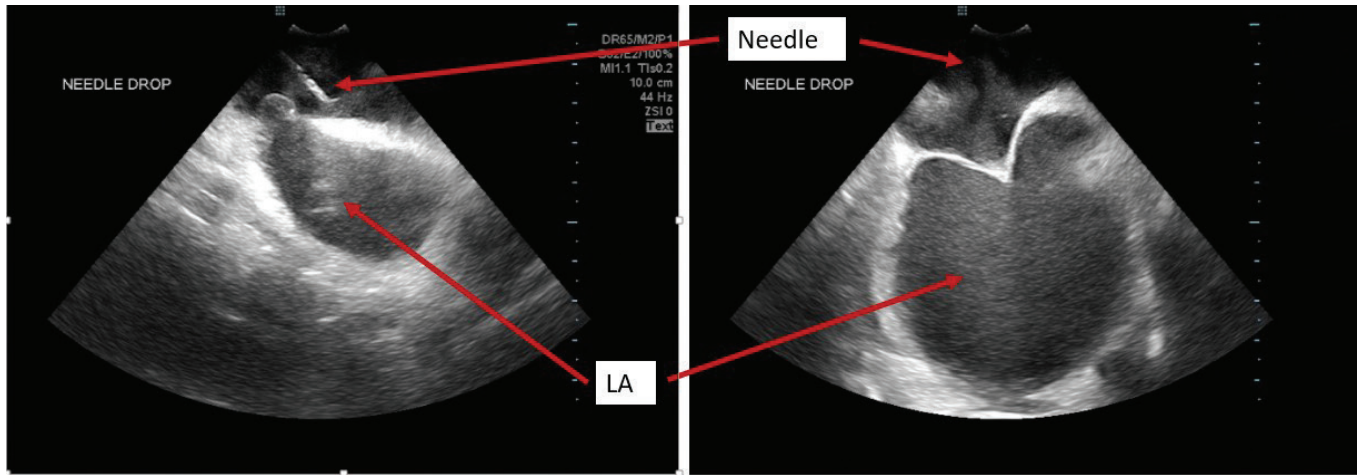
Intracardiac ultrasound (ICE). Use of ICE allows for true real-time visualization of anatomy during transeptal puncture.
